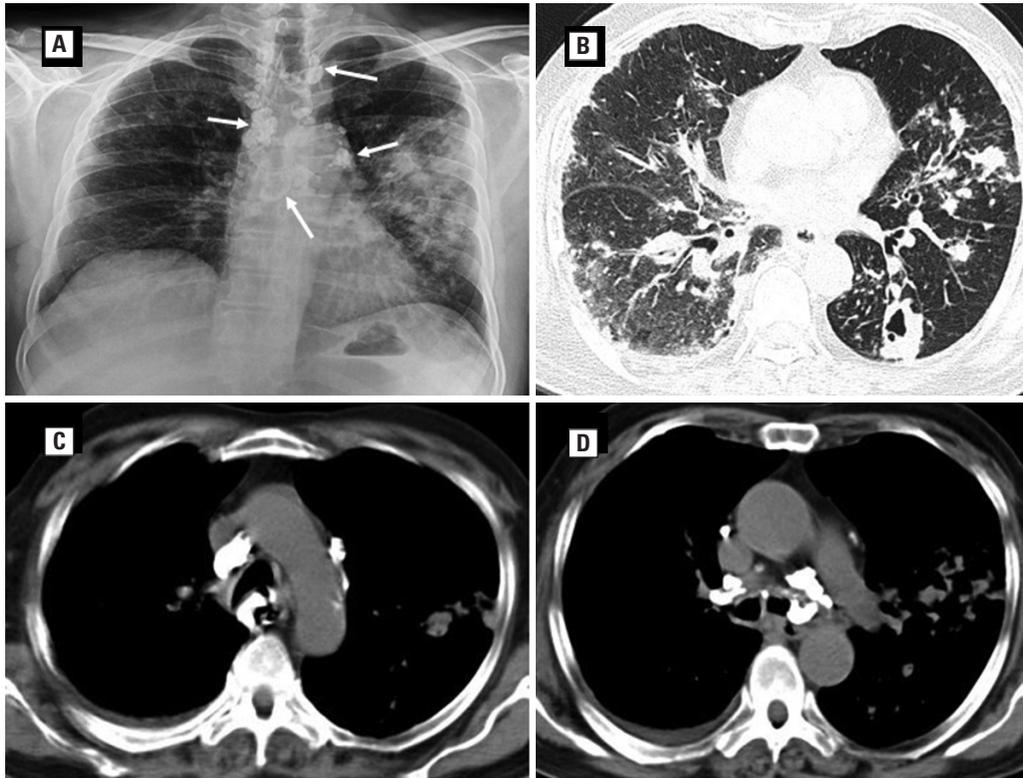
A. Chest radiograph showing multiple calcified opacities (broncholiths) in the paratracheal and peribronchial locations (white arrows) and a large patch of consolidation in the left mid zone; B. Lung parenchymal window of computed tomography (CT) of the chest showing multifocal patchy consolidation and cavities in bilateral lung fields; C. Mediastinal window of CT of the chest showing calcified subcarinal, paratracheal and para-aortic nodes in the mediastinum (extraluminal broncholiths); D. Mediastinal window showing an intraluminal bronchololith in the left main bronchus as well as extraluminal broncholiths adjacent to both main bronchi
